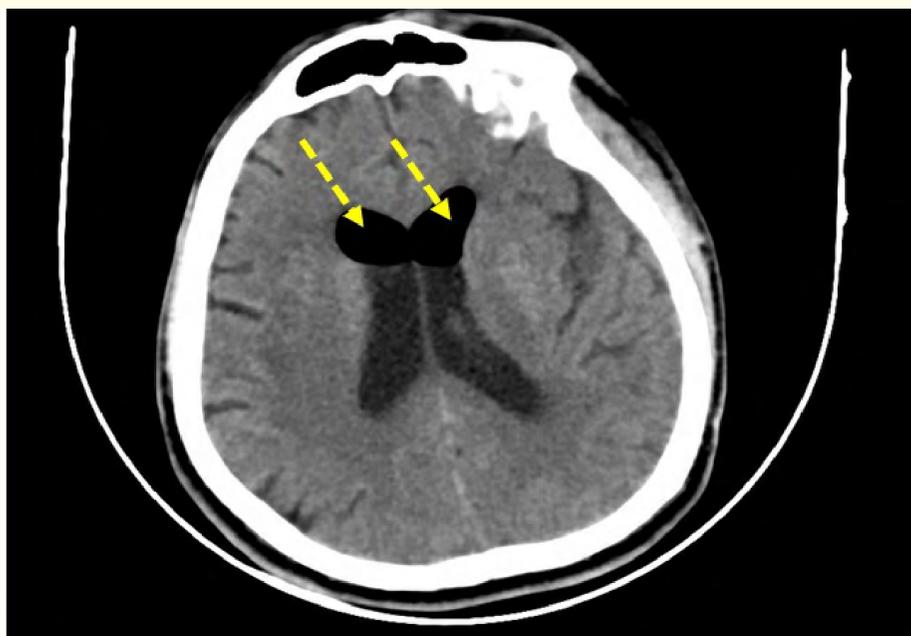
CT Brain within one hour. Focal air pocket in the frontal horn of the ventricle of the brain noted. (Shown by arrow).
